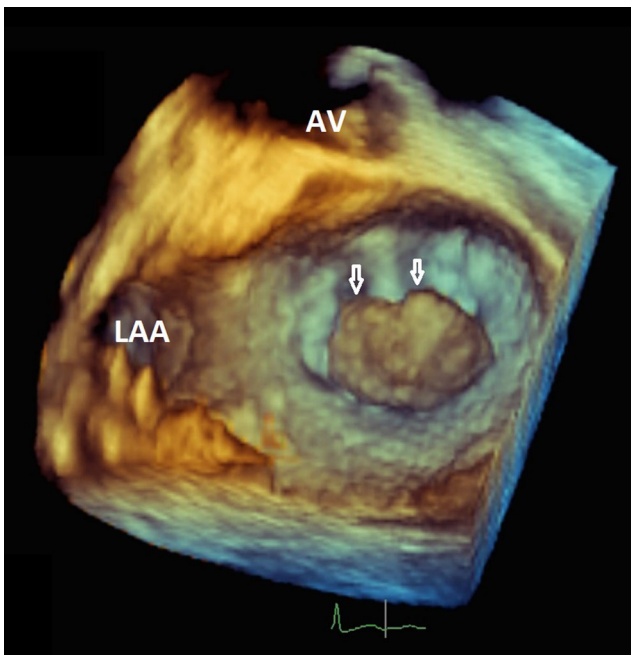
Transoesophageal 3D view from the left atrial perspective shows a large mass attached to the atrial surface of the mitral valve (*arrows*). This is the same patient as in Fig. 4
